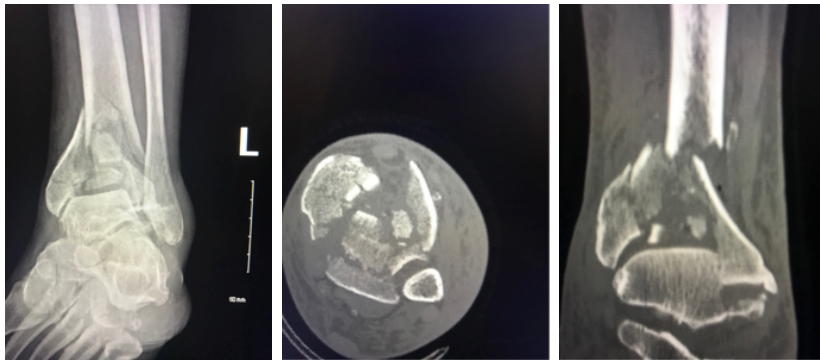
Radiograph and CT images showed the significant swelling, comminution, displacement, and bone loss of the left ankle and tibia.
